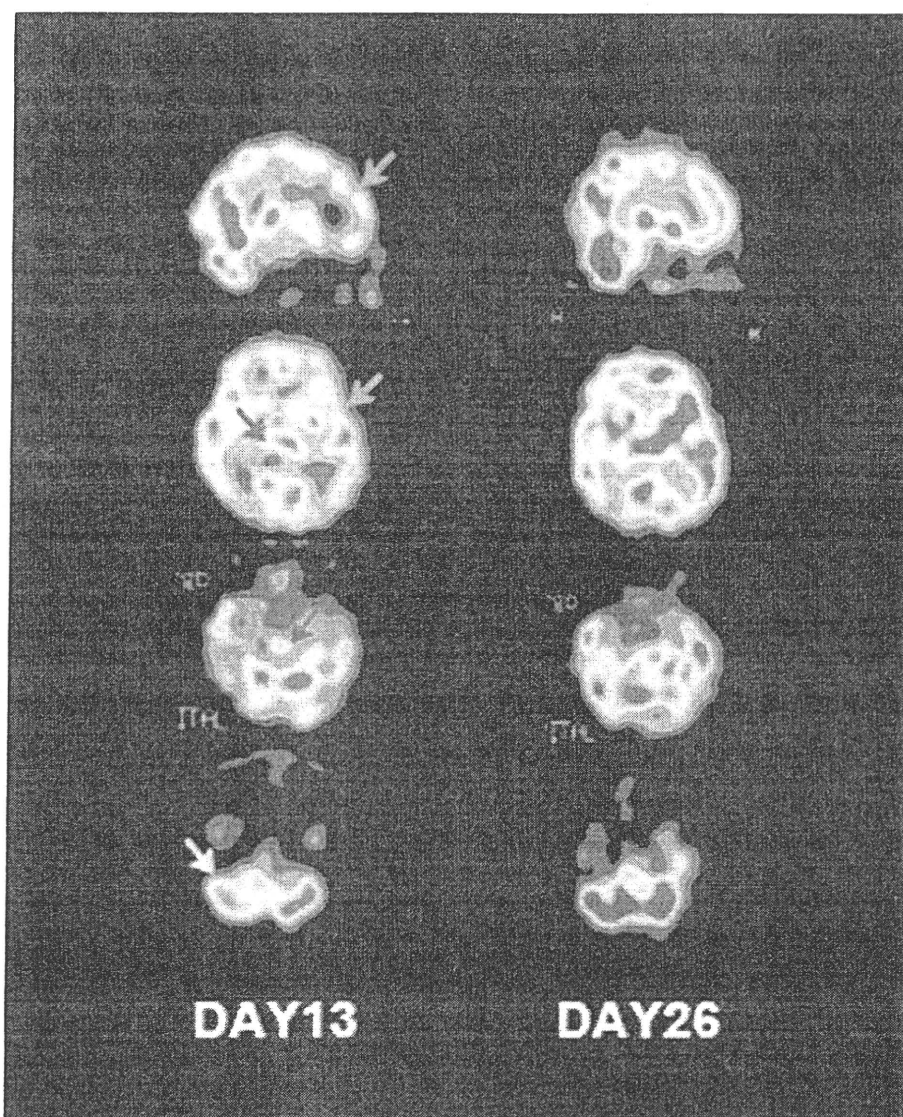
^{123}I -iodoamphetamine single photon emission CT (^{123}I -IMP SPECT) imaging of the patient. On day 13, ^{123}I -IMP SPECT reveals decreased rCBF in the frontotemporal cortex (green arrows), thalamus (blue arrow), brainstem (red arrow) and cerebellum (yellow arrow) (A). Follow-up ^{123}I -IMP SPECT on day 26 shows improvement in the damaged lesion (B).
